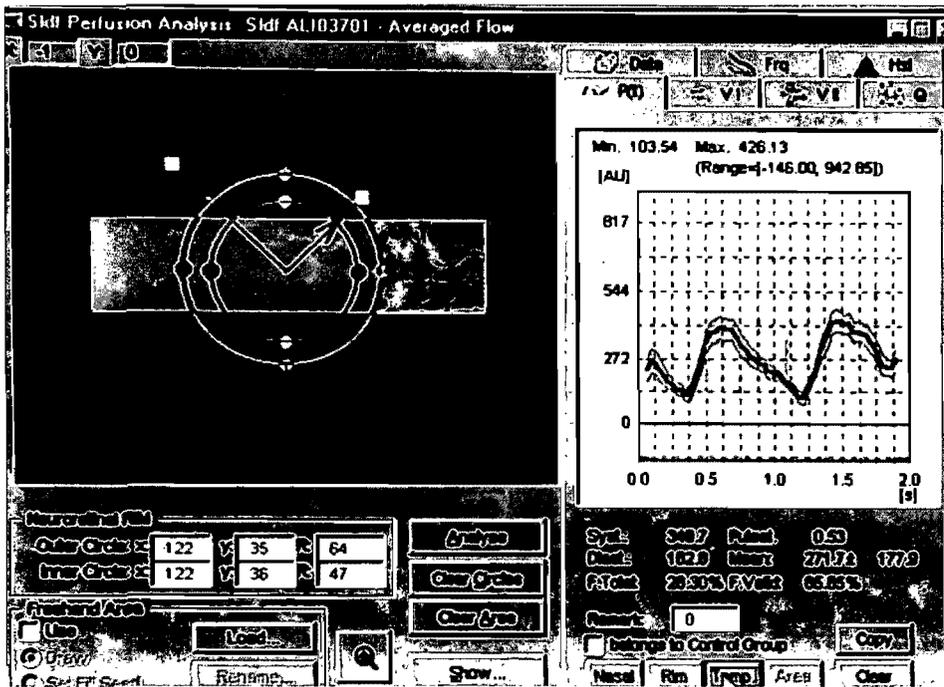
Flow image of temporal peripapillary retinal area using the scanning laser Doppler flowmetry full-field perfusion analysis showing the outline of the neuroretinal rim area (left) and a graphic presentation of the heartbeat-associated pulsation of capillary blood flow (right).
